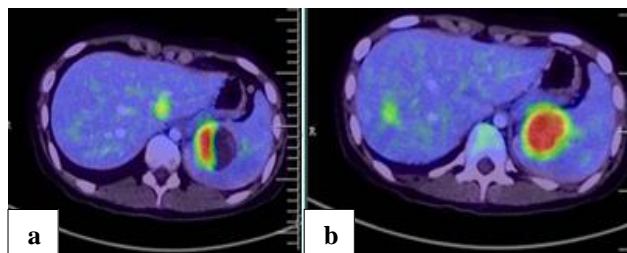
(a) PET CT showing FDG avid enhancing lesion seen in upper pole of spleen and in left lobe of liver and (b) PET CT showing FDG avid lesion in right lobe of liver.
